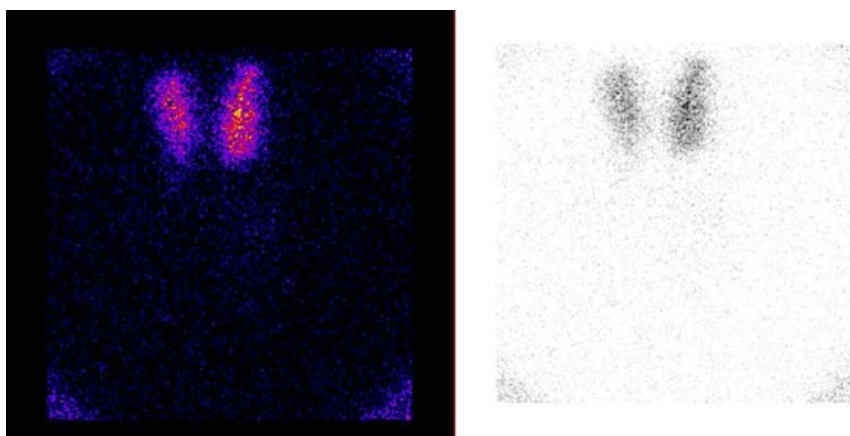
Thyroid gland radioiodine scintigraphy with ^{131}I performed with a gamma camera (Symbia E, Siemens) fitted with a high-energy, parallel-hole collimator, 24 hours after oral administration of 1.8 MBq of the radionuclide.
